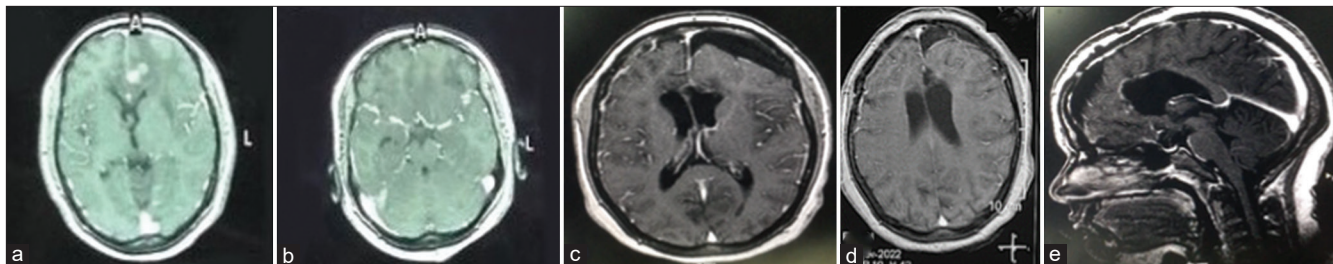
(a and b) follow up magnetic resonance imaging after six months and (c-e) 12 months, the images show the lesion's total resection.
